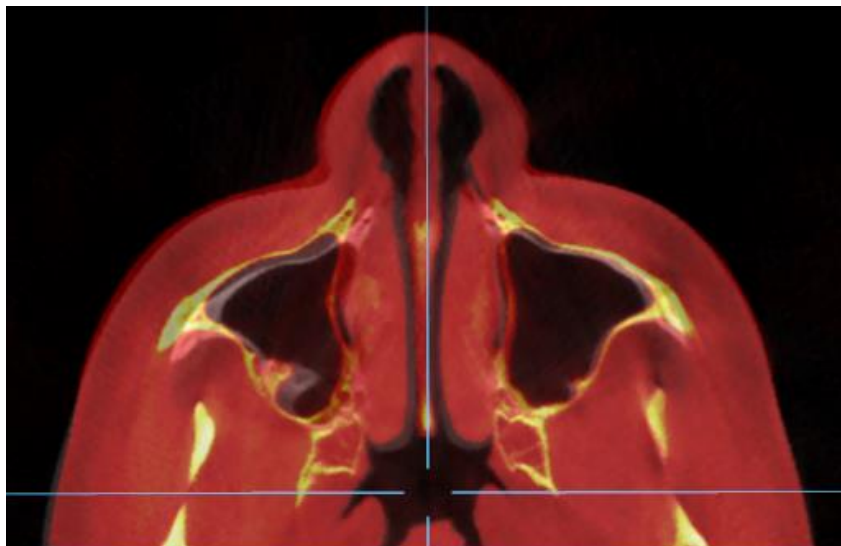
Lower nasal section (LNS): example of superimposed image of a MSE patient. The blue lines are MSP and VCP determined from the pre-expansion CBCT.
